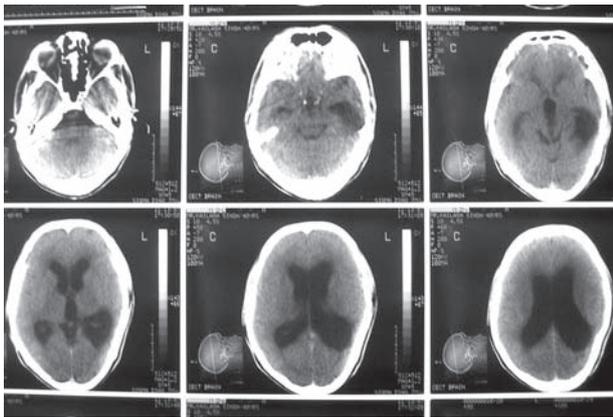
CT in the same patient six weeks later showing hydrocephalus
